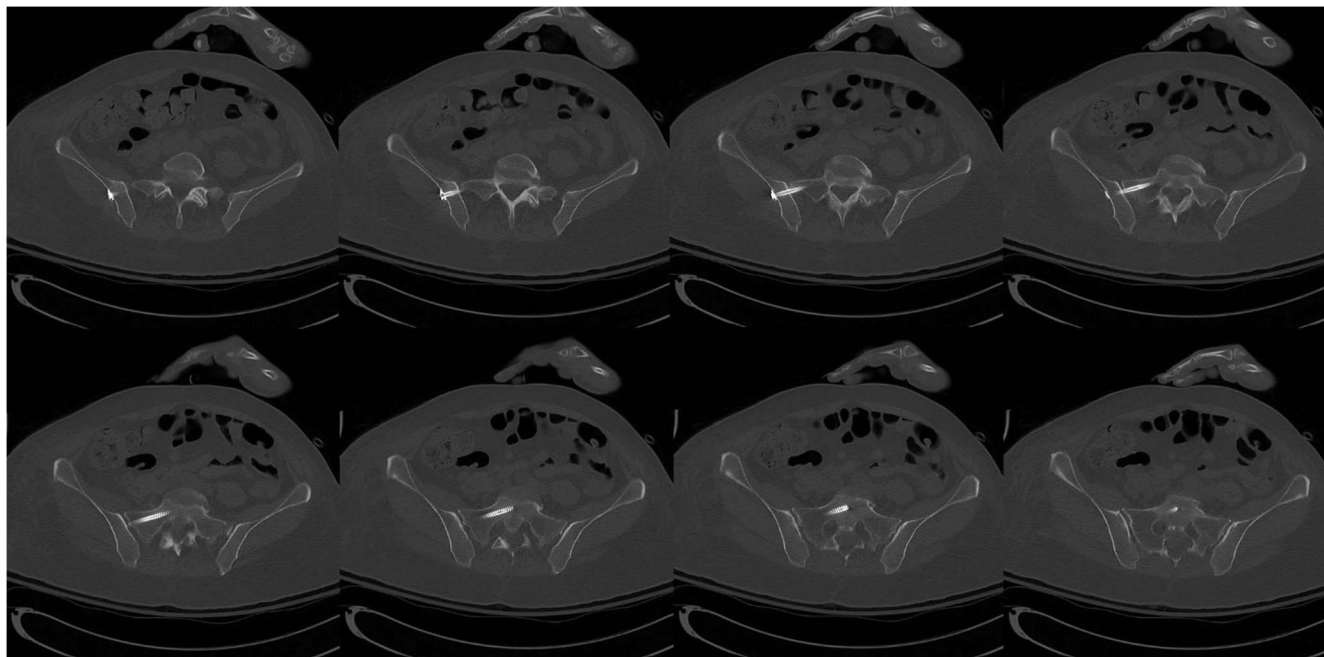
Postoperative computed tomography of the screw planned in Fig. 2.
